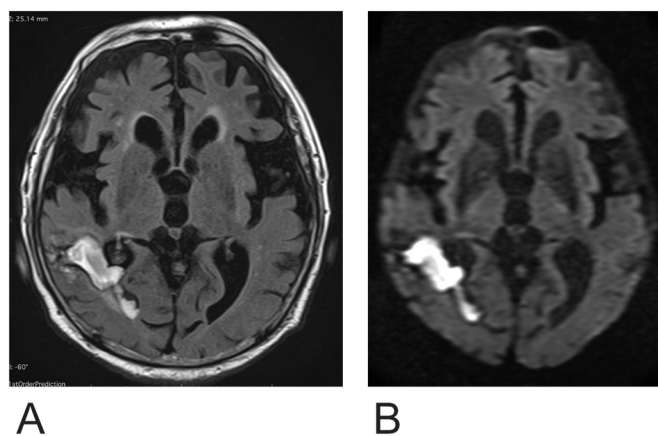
Brain MRI two months after the injury. FLAIR (A) and DWI (B) showing a high-intensity signal in the right temporal lobe that remained the same during the illness.
